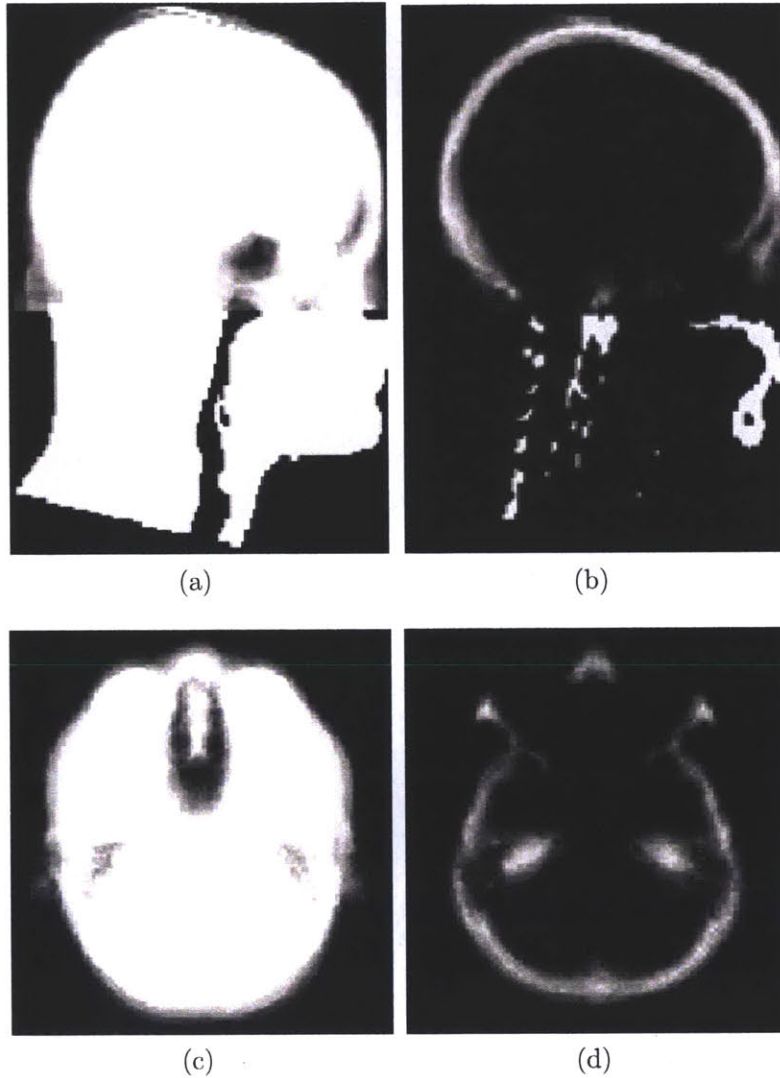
Results of the Atlas Construction. Sagittal views of the tissue/air atlas (including both soft tissue and bone) is shown in (a) and the atlas showing the probability of bone is shown in (b). The corresponding axial views are shown in (c) and (d), respectively. The probability maps account well for variability across subjects in the brain and upper head region. In the more inferior regions of the head and neck, only a single observation from the Zubal CT was available. The intensity scale is $[0, 1]$.
